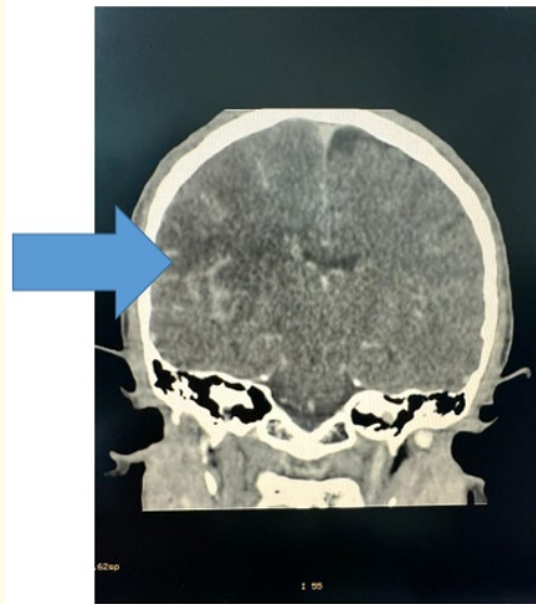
CT brain angiography coronal view shows enlarged right ICA filled with thrombus.
